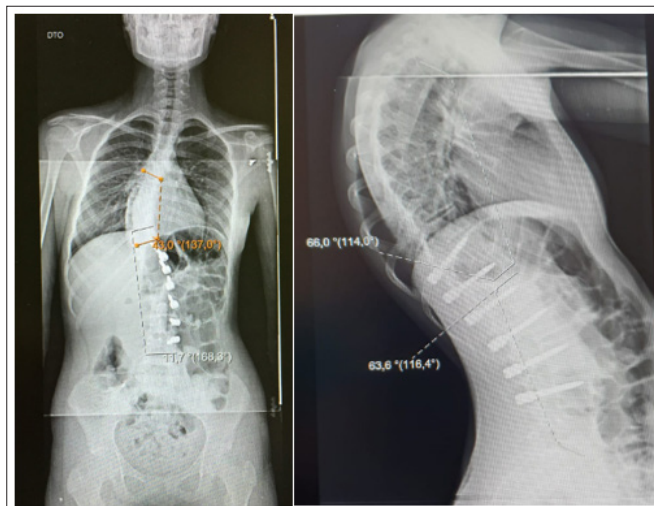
Six months radiograph after VPT procedure to the lumbar curve (standing)
